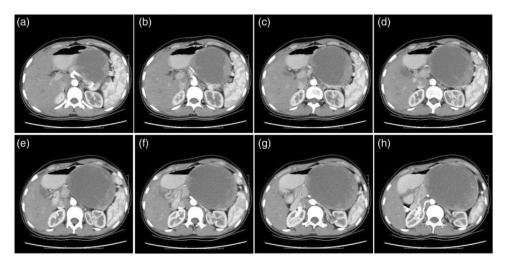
Preoperative enhanced computed tomography scan of the solid component of the neoplasm showed uneven enhancement in the arterial phase. No varicosity was observed in the stomach.
